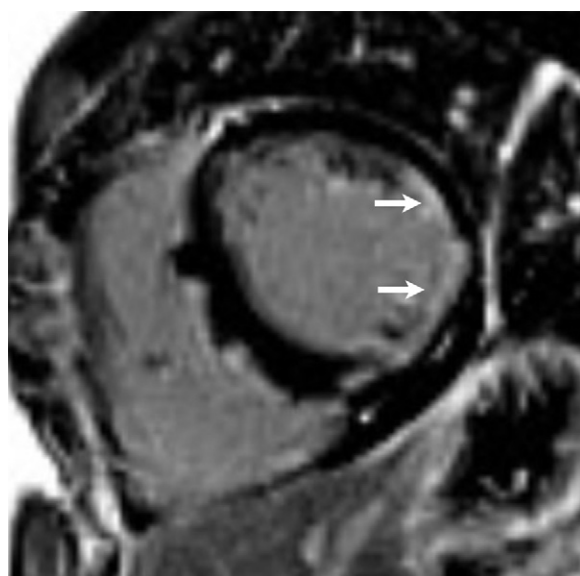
Phase-sensitive inversion recovery cardiac short-axis MR image in a 43-year-old woman with connective tissue disorder and multivessel spontaneous coronary artery dissection shows subendocardial late gadolinium enhancement in left circumflex coronary territory (arrows).
